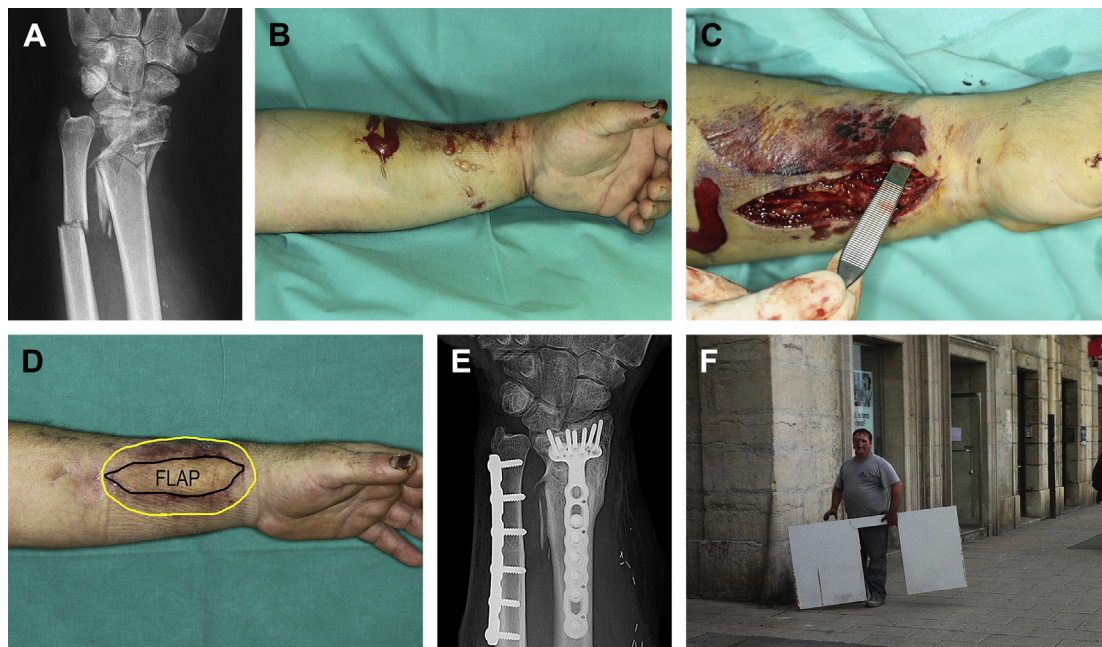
(A) This patient's forearm was crushed by a brick wall, causing comminuted fractures of the radius and a shaft of the ulna. (B) Skin and wrist swelling is evident at 12 hours. (C) Release of the distal forearm compartments and hematoma evacuation were sufficient for decompression. Although local tissue was enough to cover the plates, it was insufficient to provide a healthy environment for fracture healing and tendon gliding. Note that the skin flap is paper thin. (D) A lateral arm fasciosubcutaneous flap was used to wrap around the bone and provide a healthy fat layer for tendon gliding. Immediate range of motion was started. The patient regained nearly normal wrist motion and 115% grip strength on his affected (dominant) hand. (E) A plain radiograph taken at 1 year. (F) The patient returned to his original occupation. He was photographed here by the senior author, who happened upon him while he was working (with patient permission). (Copyright © 2015, Francisco del Piñal, MD.)
